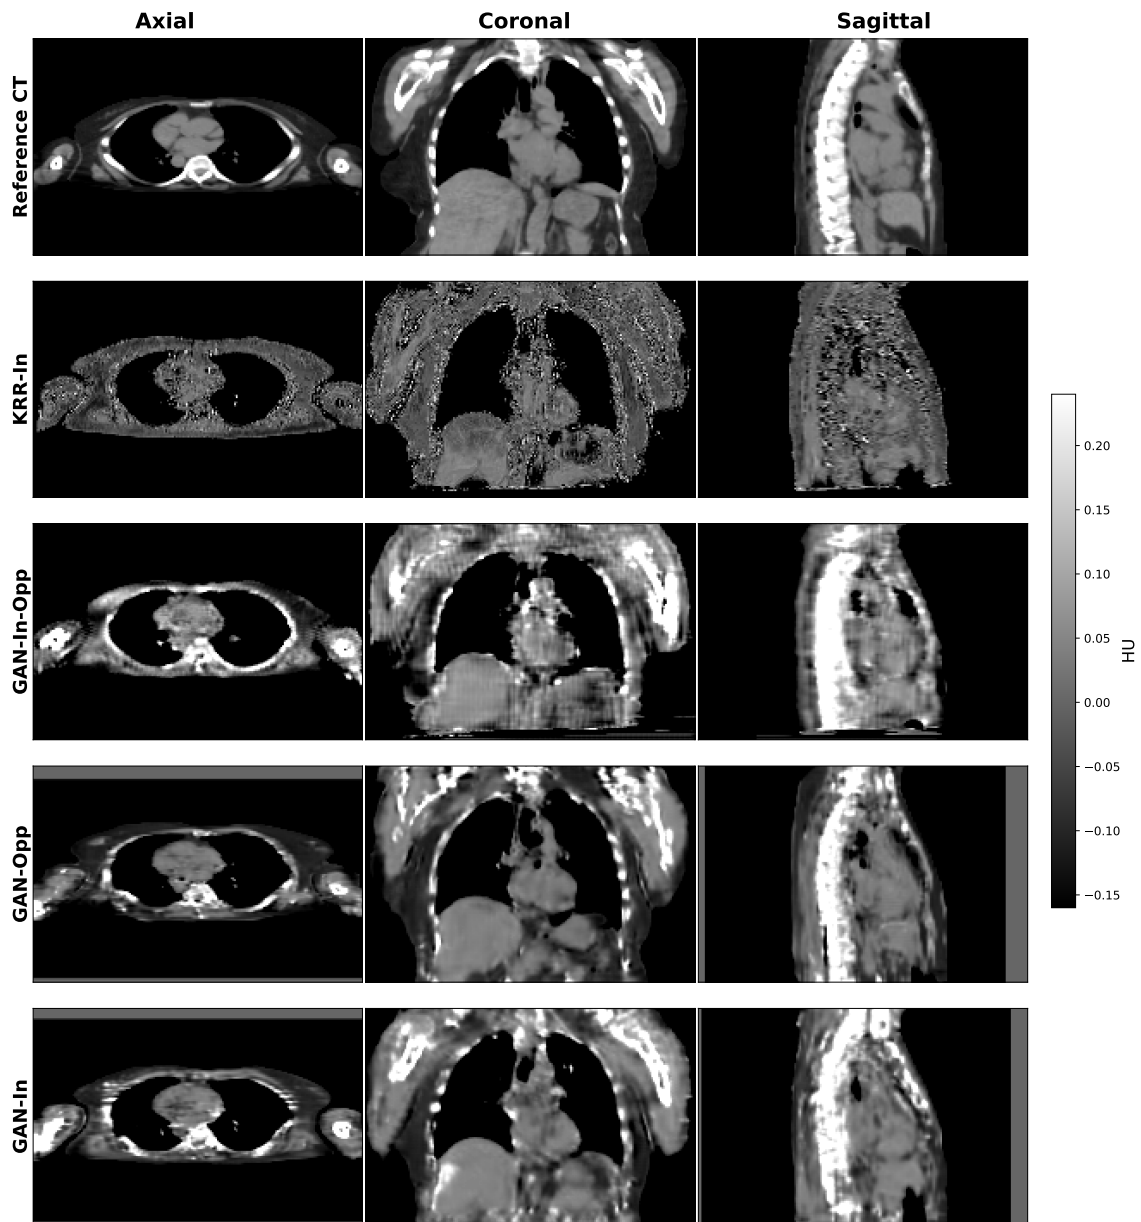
Axial, coronal, and sagittal views of a true CT slice (top row) compared to synthetic CT slices generated by KRR-In, GAN-In-Out, GAN-Out, and GAN-In models. Intensities are normalized to $[-1, 1]$, with a colorbar ranging from -0.20 to 0.20.
